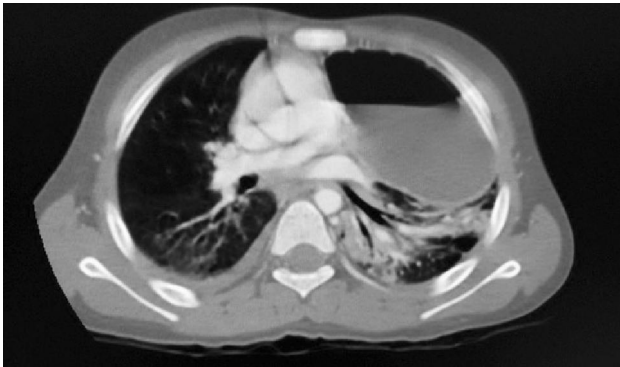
CT Scan chest in lung window setting showing contusions involving both lungs more on the left side.
